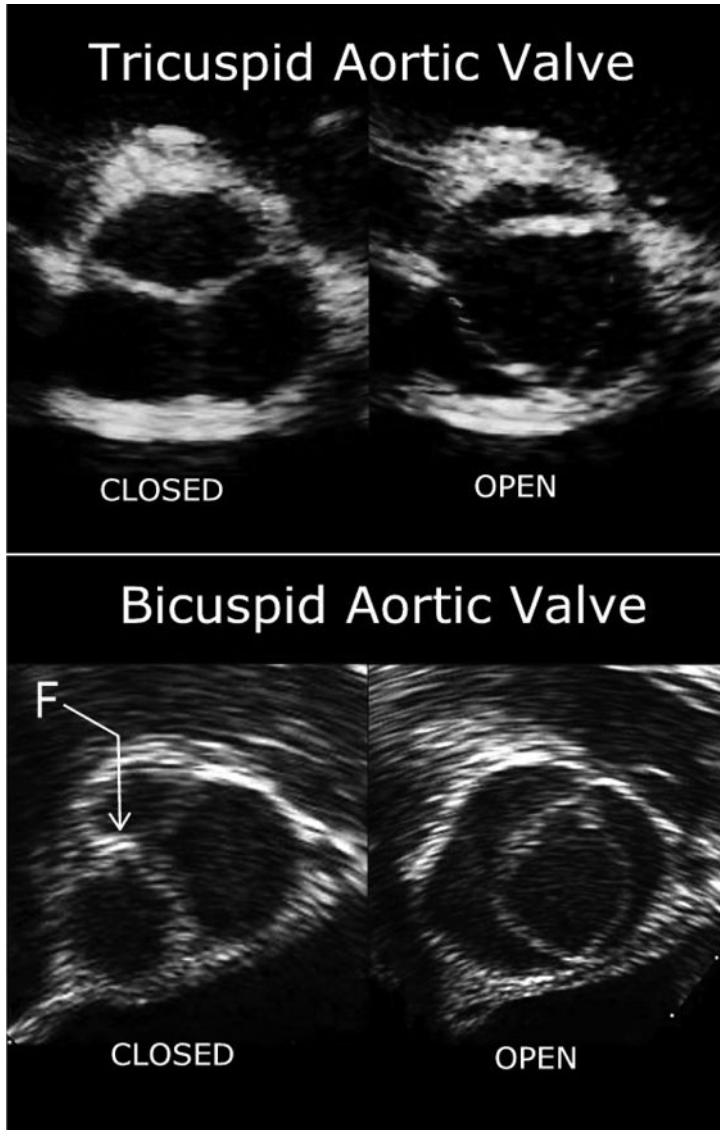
Short-axis echocardiographic views of a normal tricuspid aortic valve and bicuspid aortic valve. Fusion of two cusps (F) results in abnormal opening of the valve along two commissures instead of the normal three.
